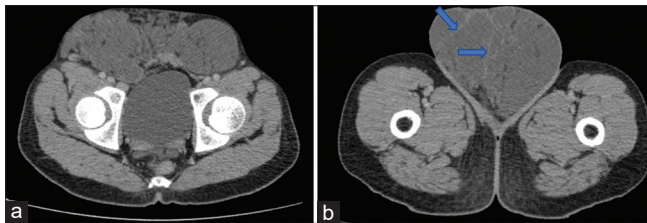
Axial postcontrast computed tomography scan showing dilated lymphatic channels (a) in the bilateral inguinal region and its extension up to scrotum (b) with enhancing septae (blue arrows) within it
